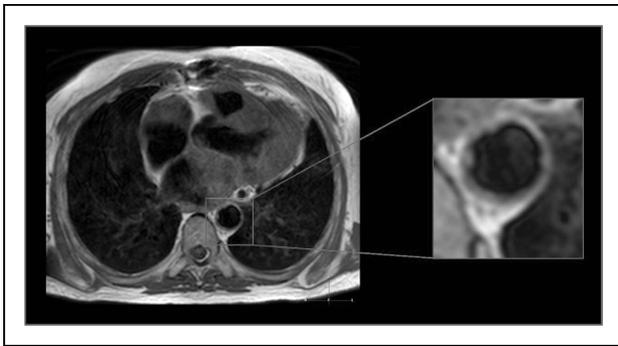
Pericardial fat can be expanded in otherwise lean but metabolically unhealthy patients. MRI images of a metabolically unhealthy, lean (MUL) patient, showing ectopic fat deposition consistent with previous reports of ectopic adipose tissue accumulation [27,28] in such patients. An axial T1-weighted black-blood image obtained through the thorax shows pericardial fat (bright regions surrounding the heart) and aortic atherosclerosis (shown in the box enlargement) (irregular thickening of the vessel wall) in a nonobese individual with metabolic syndrome. There is also prominent fat surrounding the coronary above the aorta.
